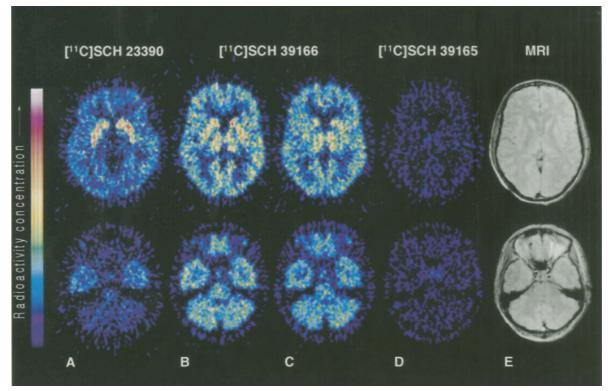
A-E Horizontal PET images at the level of striatum (upper panels) and cerebellum (lower panels) in healthy males after IV injection of [¹¹C]SCH23390 (A), [¹¹C]SCH39166 high (B) (subject 5) and low (C) (subject 5) specific radioactivity, [¹¹C]SCH 39165 (D) (subject 5). In E a corresponding MR image is shown. PET images show accumulated radioactivity 9-63 minutes normalized to injected dose of radioactivity.
